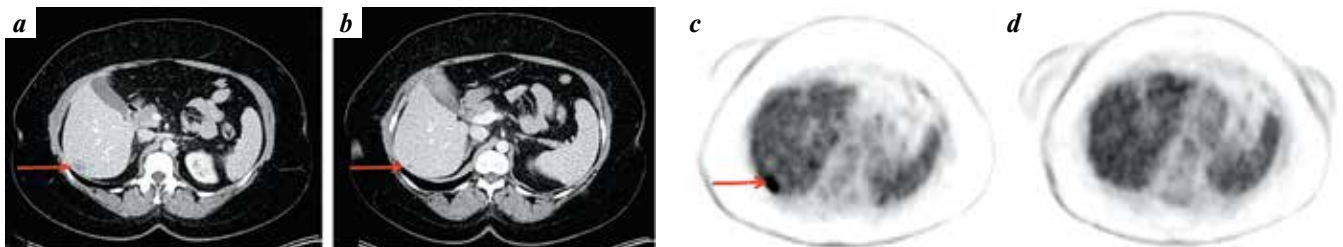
Results of patient examination: contrast-enhanced computed tomography (CT) scan before (a) and after (b) treatment; ^{18}F -fluorodeoxyglucose positron emission tomography scan before (c) and after (d) treatment; axial view. Metastasis in the right lobe of the liver in the S6 segment. Pretreatment scans demonstrate focal accumulation of radiopharmaceutical in a single hypovascular formation of the right lobe of the liver; posttreatment scans demonstrate reduced size of this formation (b) and no focal metabolic activity (d)
